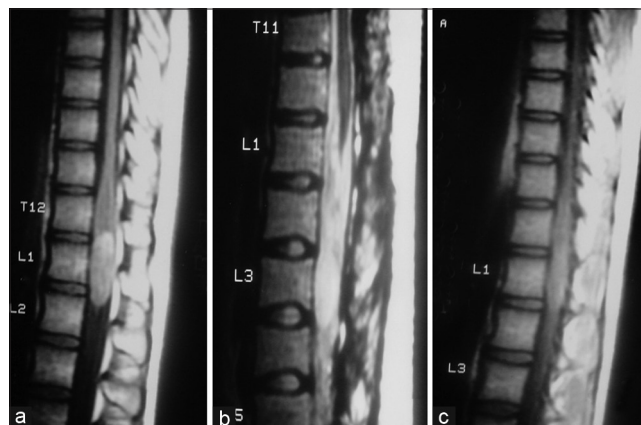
(a) MRI thoracolumbar spine T1W, (b) T2W and (c) contrast enhanced sequences showing intramedullary mass at conus taking up the contrast
